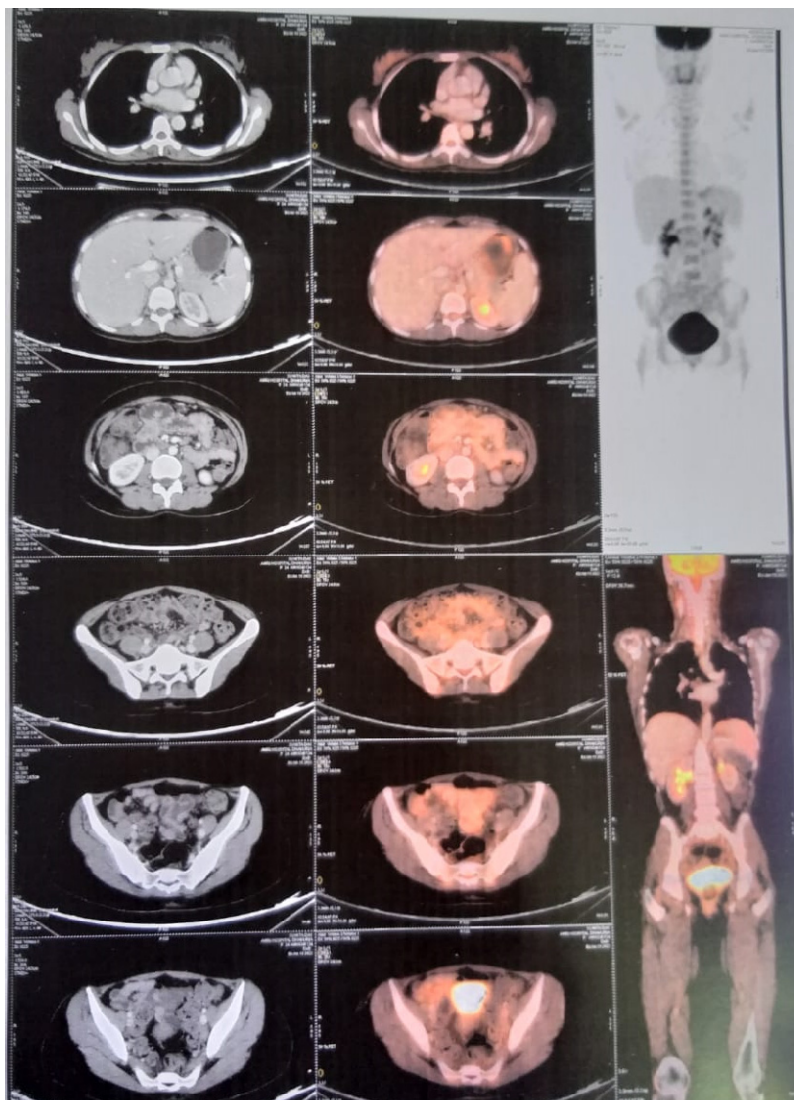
PET-CT image showing mild splenomegaly and metabolically active mesenteric lymph nodes, suggesting an inflammatory/reactive process rather than malignancy.
